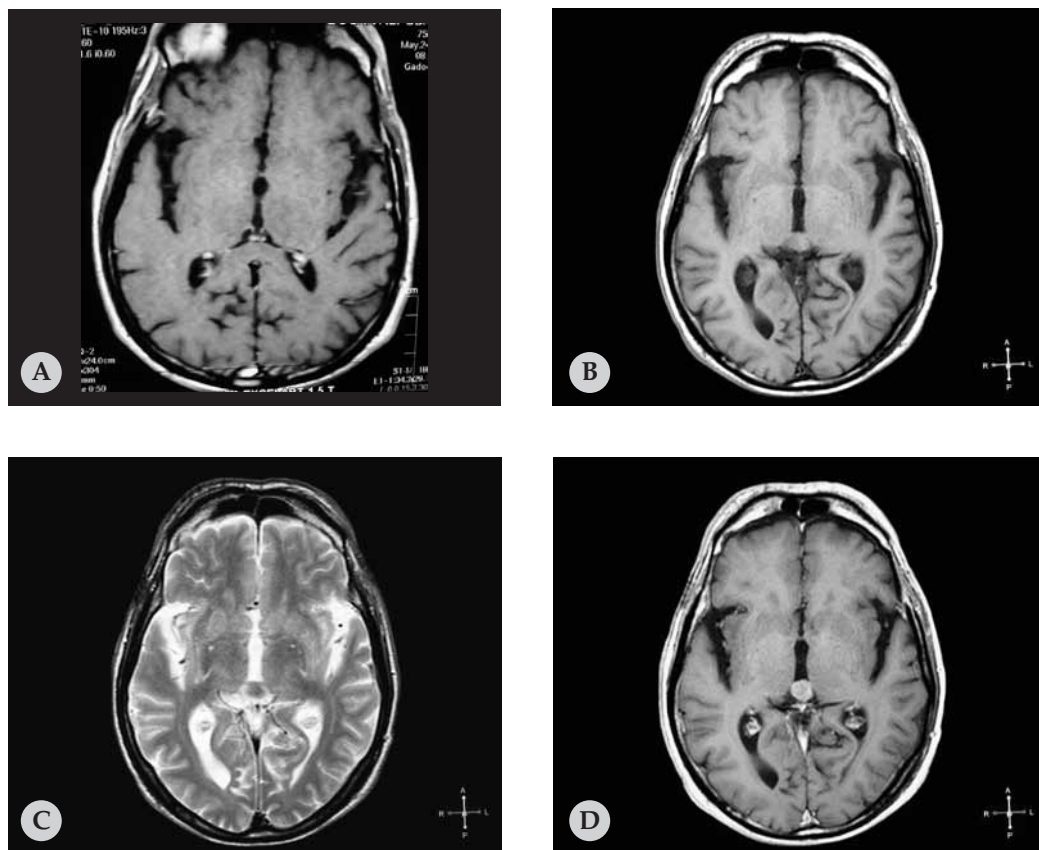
(A) Axial postcontrast T1-weighted image was normal when the patient was admitted to the hospital 10 months earlier. (B) Pineal mass is isointense on T1-weighted, (C) and uniformly hypointense on T2-weighted images. (D) Postcontrast T1-weighted axial images demonstrate uniform contrast enhancement.
